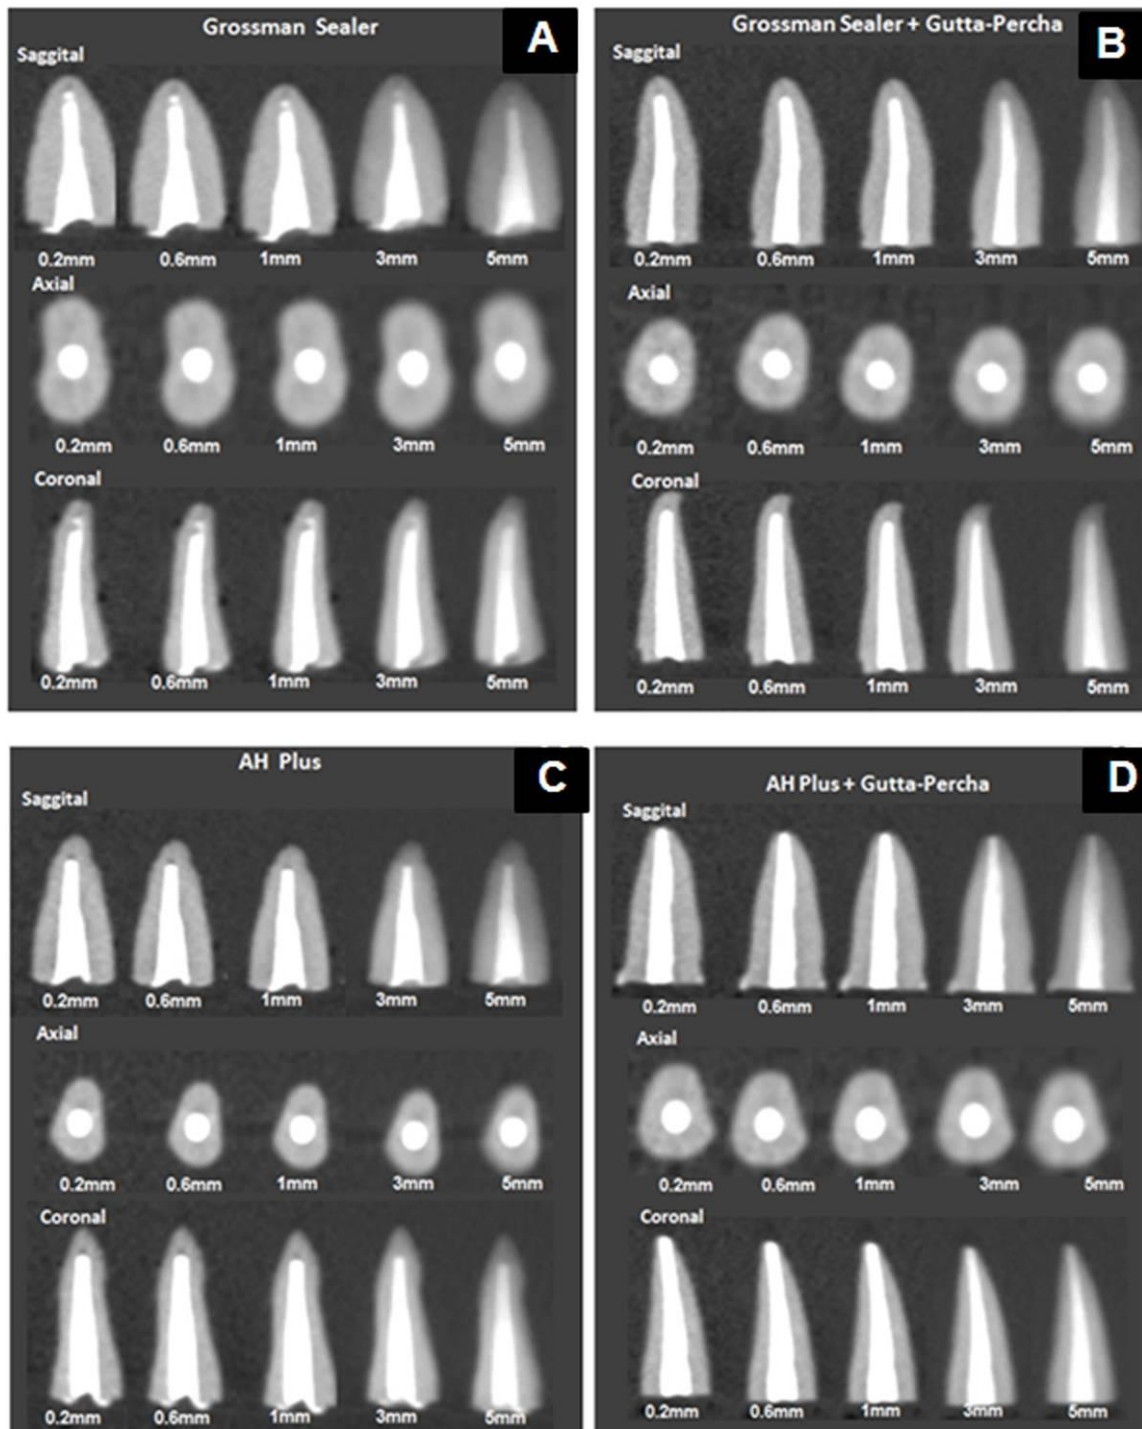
CBCT images of root canal filling with Grossman Sealer (A), Grossman Sealer 26 + gutta-percha (B), AH Plus (C), and AH Plus + gutta-percha (D) in different slice thickness and planes (sagittal, axial and coronal).
